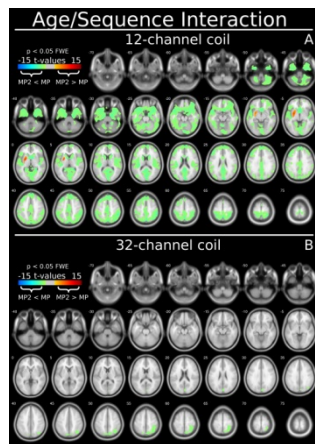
Interactions effect of age and MRI sequence in acquisitions with (A) the 12-channel and (B) the 32-channel coil.
